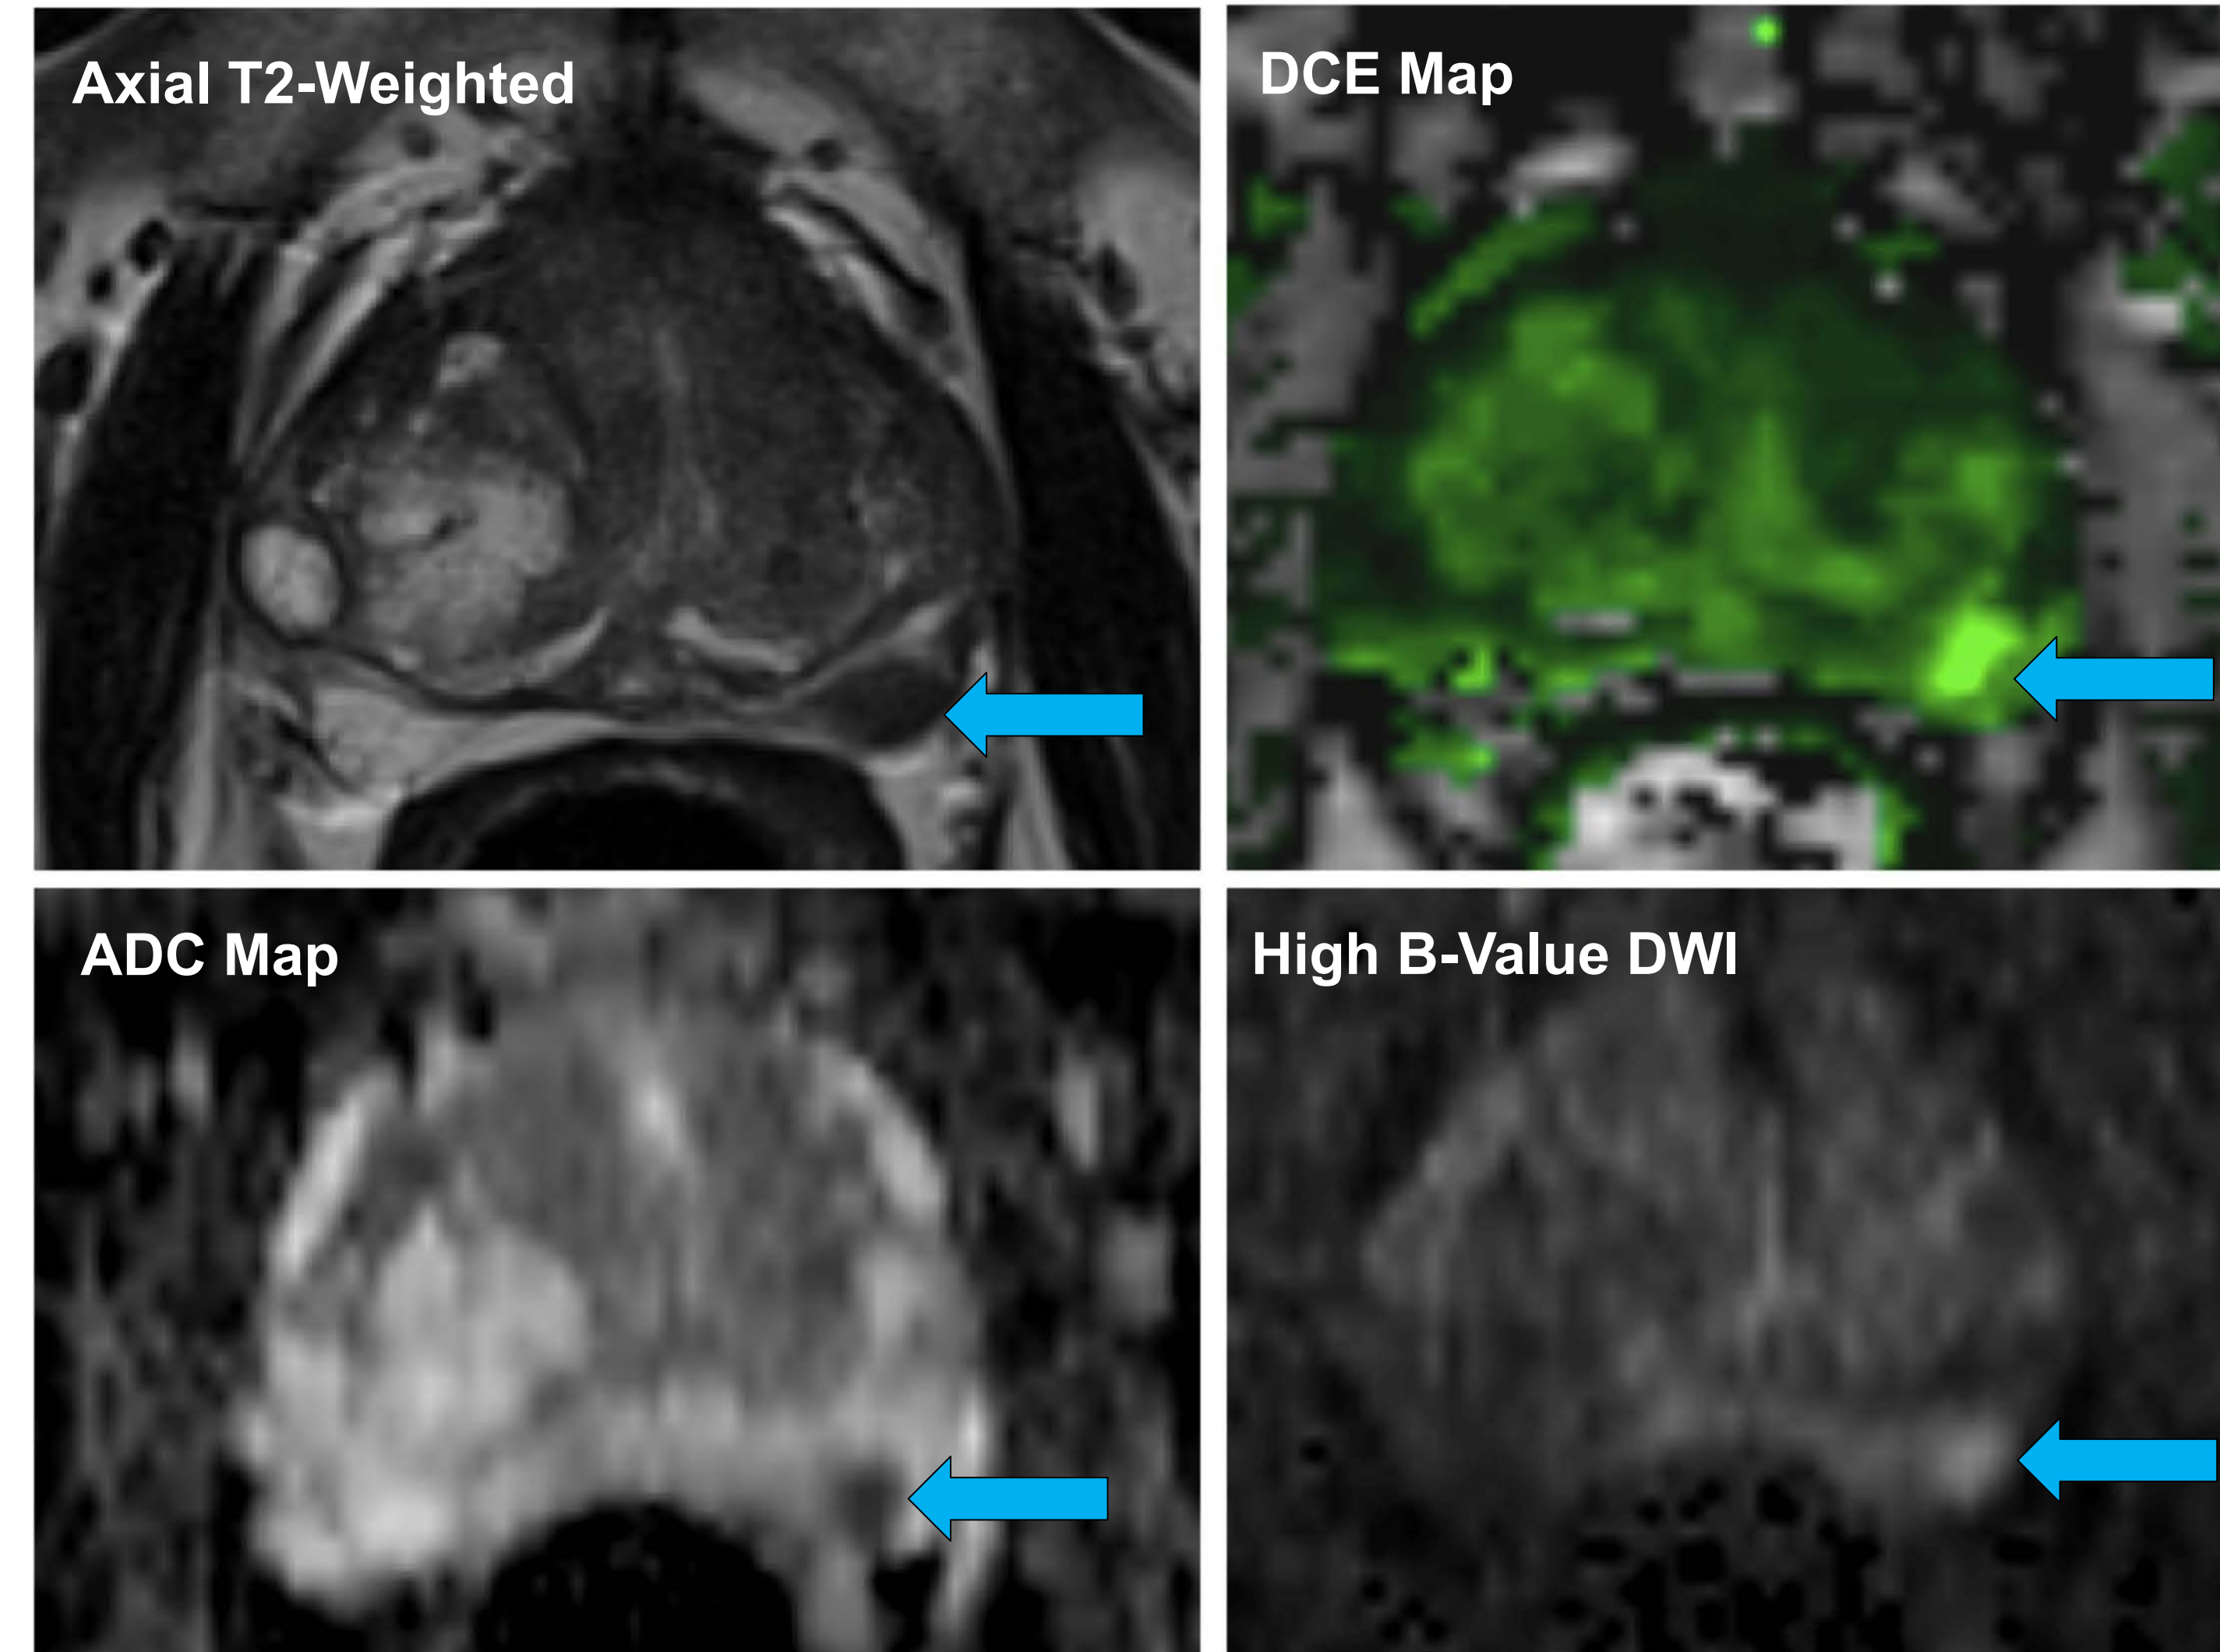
mpMRI demonstrating PI-RADSV2 Grade 5 region of interest (ROI) in left peripheral midgland (arrows). MRI/US fusion biopsy of ROI yielded 2 cores of Gleason 3+3=6 CaP. (68 y.o. WM with PSA=6.4 ng/ml and prostate volume=61cc.)
